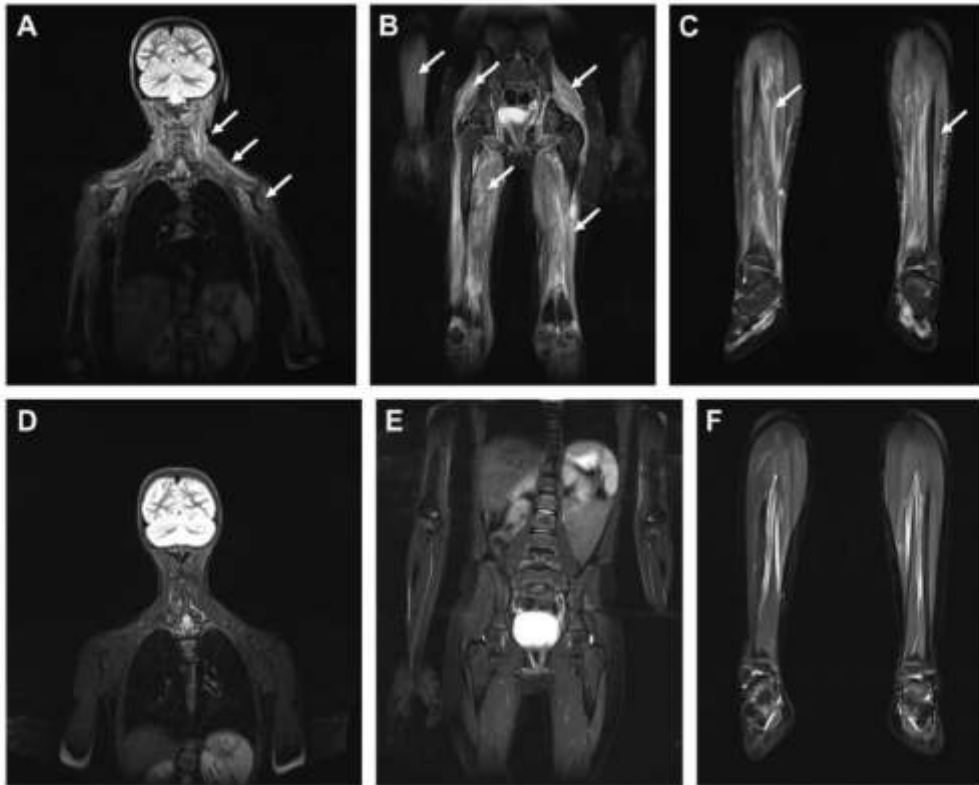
Whole body MRI in an A 6-year-old girl with juvenile dermatomyositis. Coronal T2 TIRM images. Initial examination (A-C) shows multiple areas of increased signal in muscles of the neck, upper and lower girdle, forearms and crura; follow-up 8 months later (D-F) shows complete resolution of all lesions.
